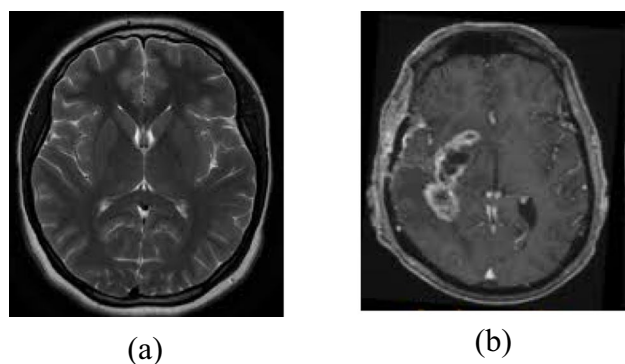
Brain MRI images. a Normal brain MRI. b Brain MRI with tumor
